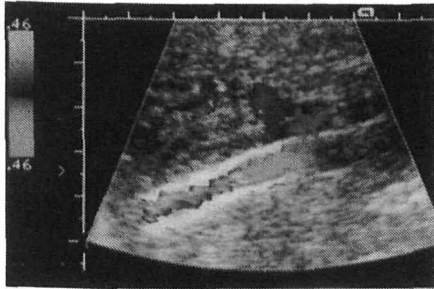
TIPS in two different patients. (a) Sonogram obtained in a 52-year-old woman shows the walls of the bent stent as a row of echogenic dots that correspond to the metallic wires. The slightly everted end is seen entering the portal vein. (b) Sonogram obtained in a 45-year-old man shows the prosthesis in its complete length. The smooth curvature of the stent contributes to the optimal hemodynamic orientation of the shunt with respect to the decompressed portal vein (\*) and the draining hepatic vein (arrows).
